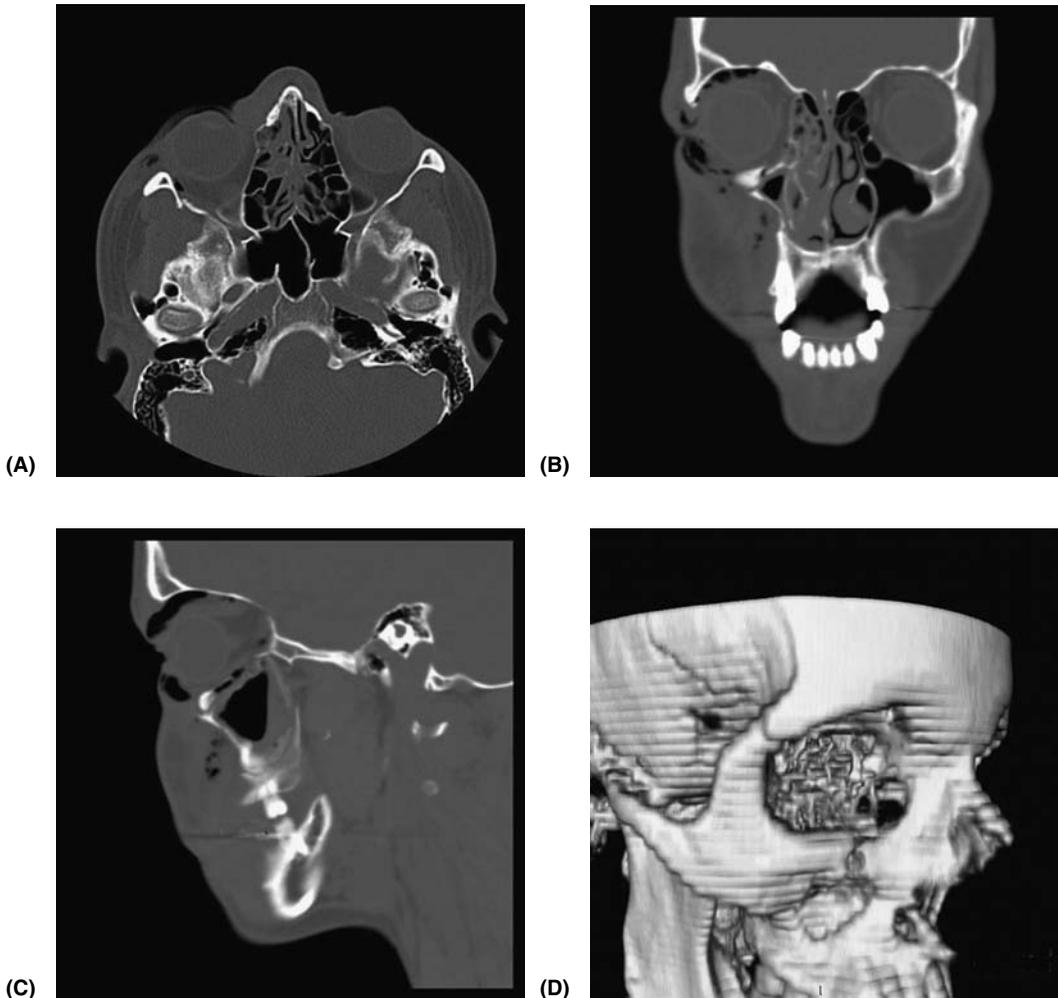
Computed tomography (CT) (A) axial, (B) coronal, and (C) sagittal images. (D) Three-dimensional CT reconstruction.
